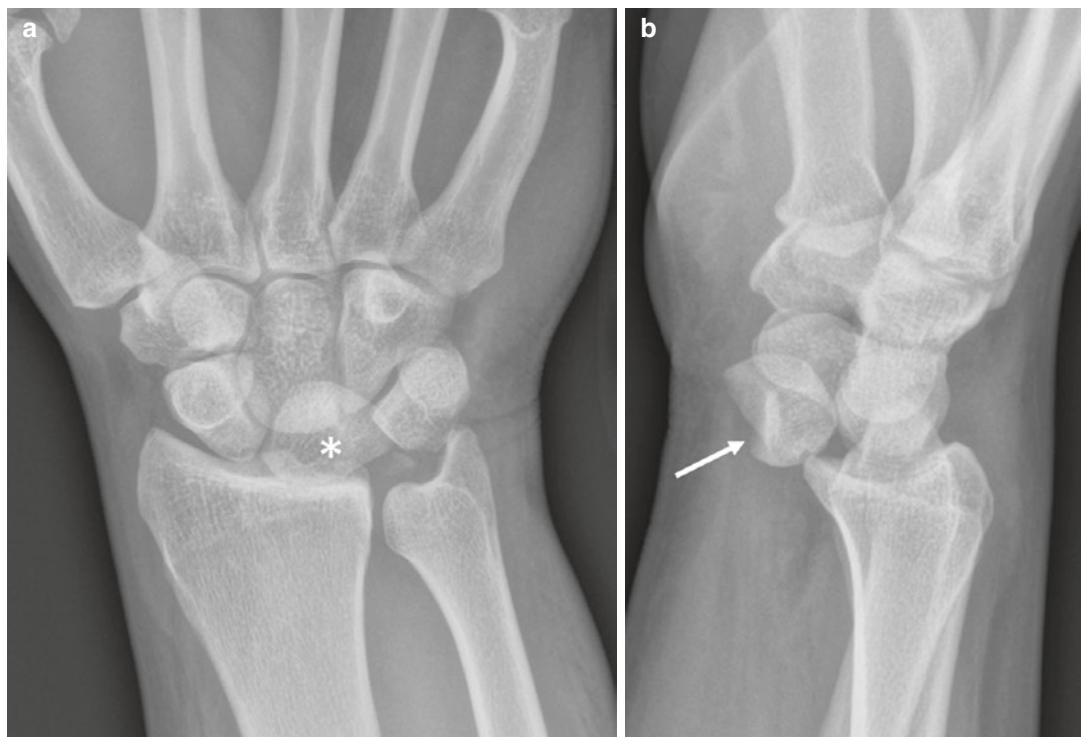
Twenty-eight-year-old man with right hand and wrist pain following motor vehicle collision. PA radiograph of the wrist (a) shows a “pie-shaped” appearance of the lunate (asterisk), a small ossific fragment at the ulnar margin of the lunate, and disruption of the “arcs
